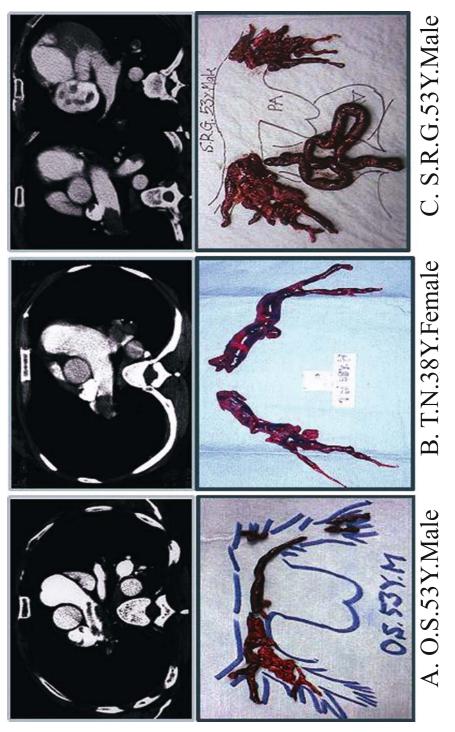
Preoperative computed tomography (CT) and surgically removed thrombi. A A 53-year-old man, hospitalized with dyspnea and given emergency surgery. This case was a combination of acute stage and subacute stage of several weeks duration. B A 38-year-old woman, onset after cesarean section. C A 53-year-old man, onset after lower limb orthopedic surgery
